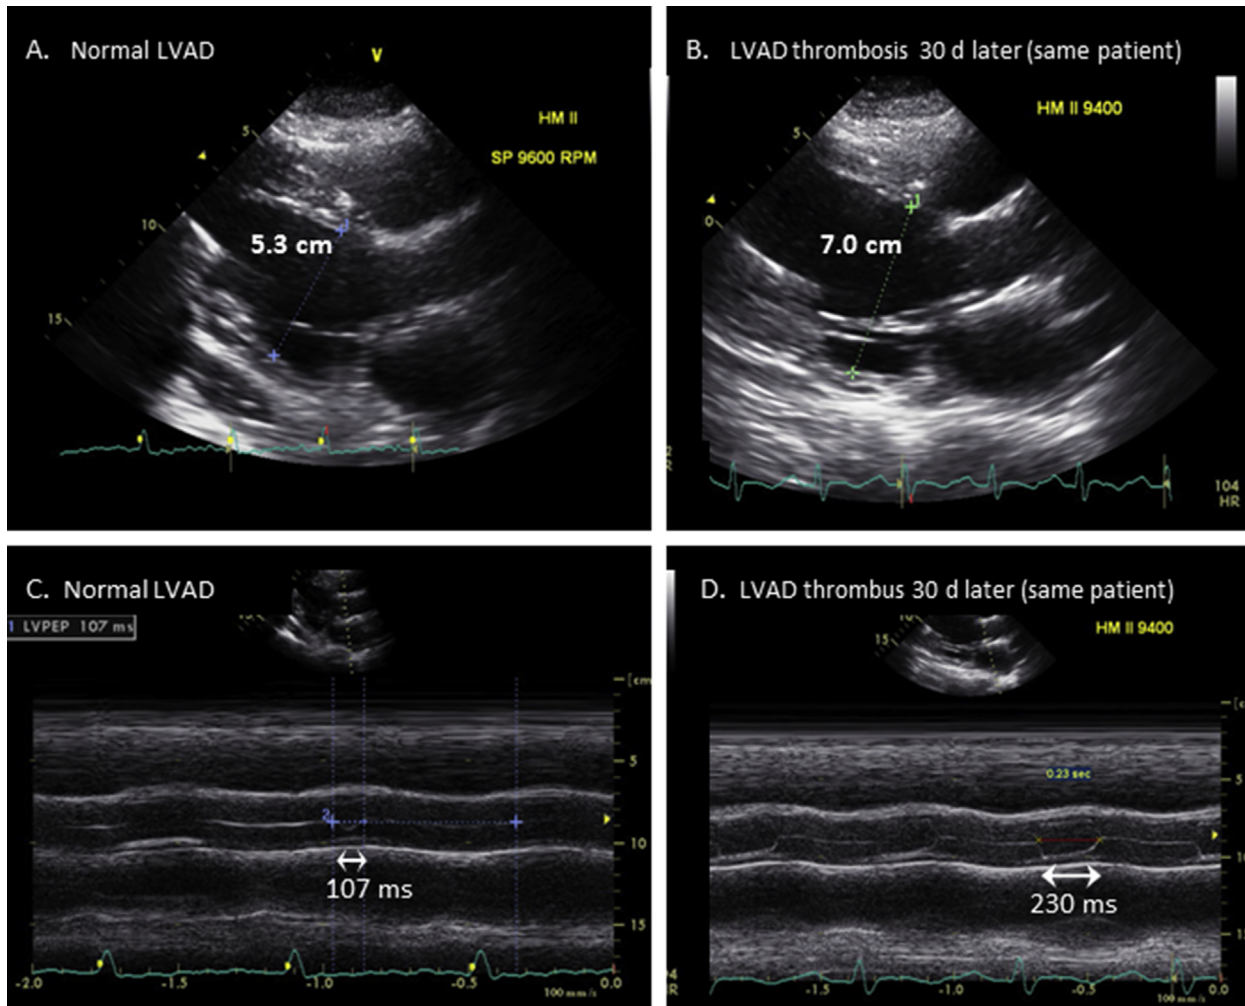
Side-by-side comparison of multiple imaging metrics in the same patient before and after HM-II LVAD impeller thrombosis. (A) LVVIDd, normal LVAD; (B) increased size by LVVIDd after LVAD thrombosis; (C) AV M-mode, minimal opening (107 ms) during normal LVAD function; (D) markedly increased AoV opening duration (230 ms) after internal LVAD thrombosis; (E,G) Inflow-cannula color-flow (arrow) and pulsed Doppler images, respectively, during normal LVAD function (see also Video 20); (F,H) Very low velocity inflow-cannula systolic flow on color-flow (arrow) and pulsed Doppler images, respectively, with nearly absent diastolic flow (view H) after development of impeller thrombosis; (I) RVOT pulsed Doppler VTI = 15 cm during normal LVAD function; (J) RVOT pulsed Doppler VTI = 7.9 cm after LVAD thrombosis. *Inflow*, inflow cannula; *vel.*, velocity.
